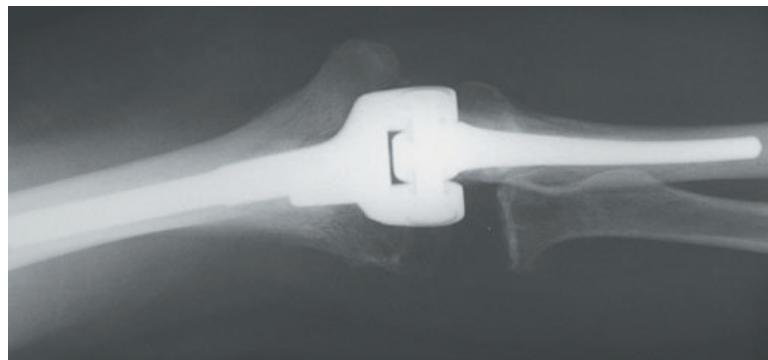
X-ray of elbow joint replacement
